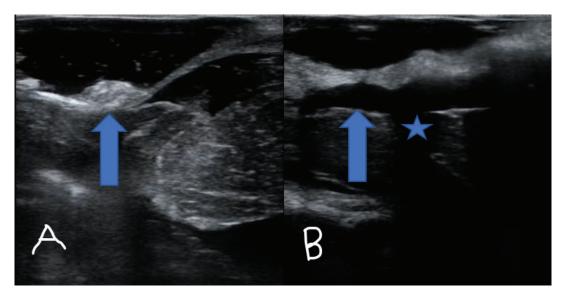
Intraoperative ultrasonographic picture (A) before decompression (B) after decompression. Blue Arrow shows the subdural CSF flow. Blue star shows flow through foramen of magendie
